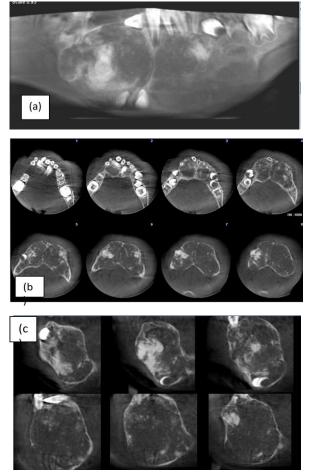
CBCT views of the lesion that shows the cortical expansion and the odontome-like calcifications in the lesion.
